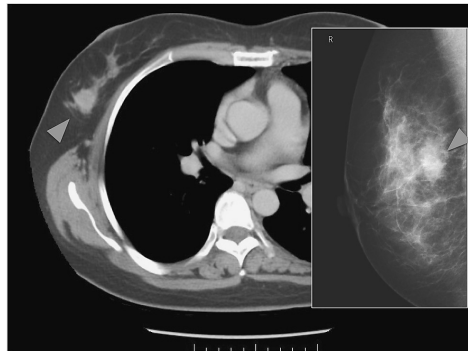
Mammography and Computed Tomography scan revealed a 15 mm diameter right breast mass with an irregular rim in the CD region.
